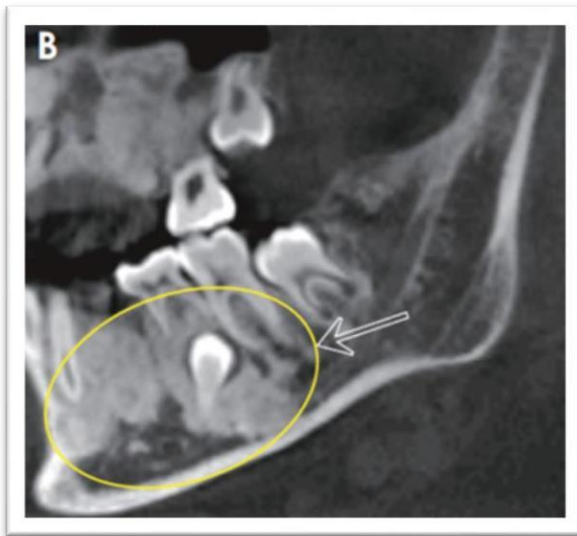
The Sagittal section of CBCT of the same patients depicting the dense bone islands adjacent to the left impacted mandibular second molar (white arrow). Adapted from Koh et al. (186)
